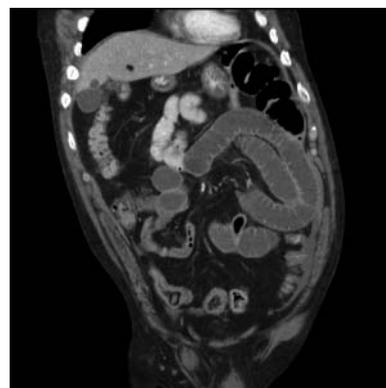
Postintravenous contrast coronal abdominal CT image. The CT image demonstrates dilated proximal small bowel loops and collapsed distal small bowel.
